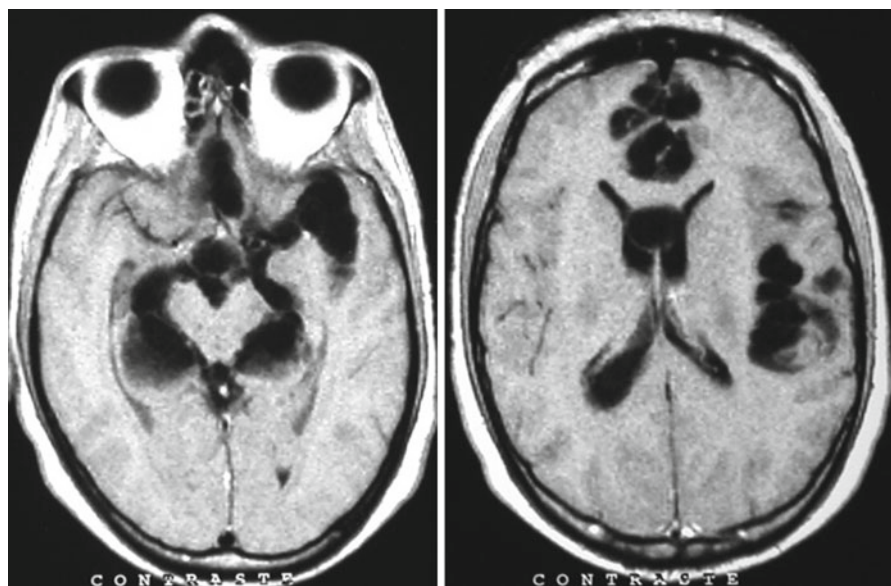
T1-weighted MRI showing clumps of subarachnoid cysticerci involving the left Sylvian fissure and the basal CSF cisterns surrounding the midbrain
